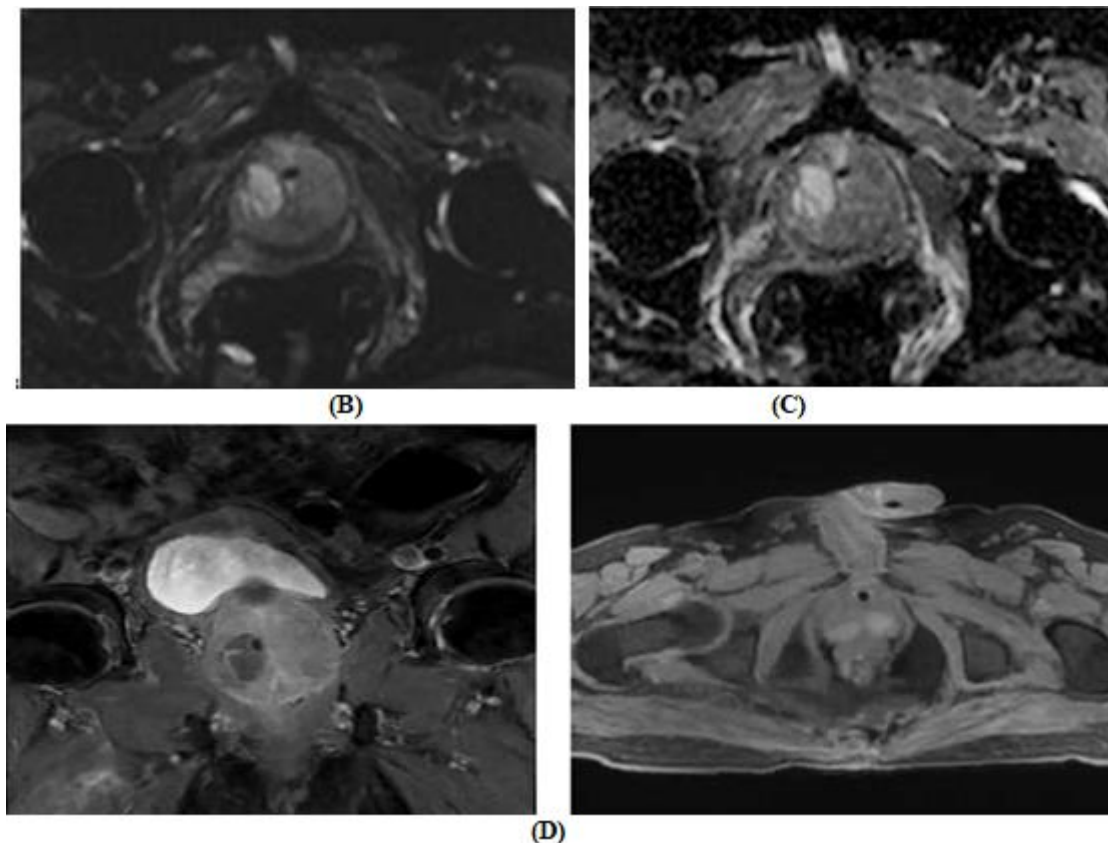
A T2W axial, B DWI at b 2000 axial, C ADC map axial, D Post contrast T1 axial and coronal
